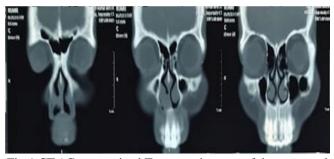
CT / Computerized Tomography scan of the paranasal sinus with contrast and the result was found anterior septum mass, homogenous lesion with soft density in the right nasal
